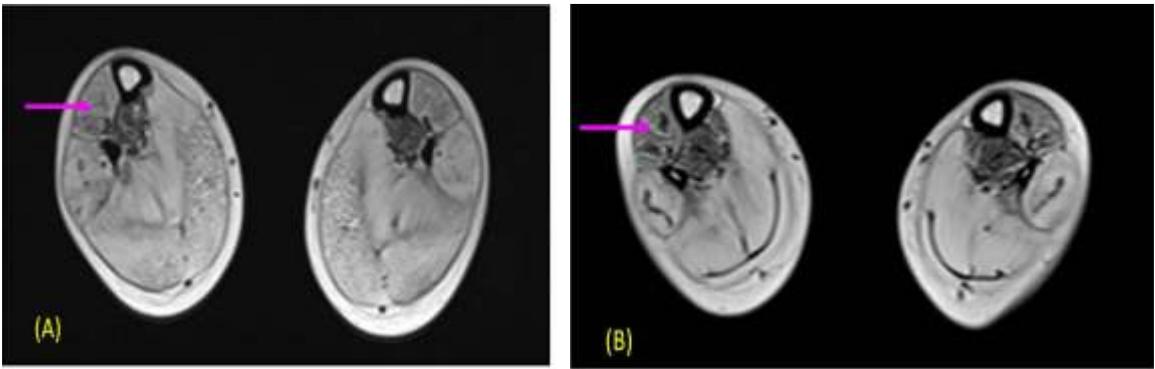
The figures A & B show MRI Musculoskeletal images before and after stem cell therapy, respectively. Regeneration of muscles is seen in Figure B.
